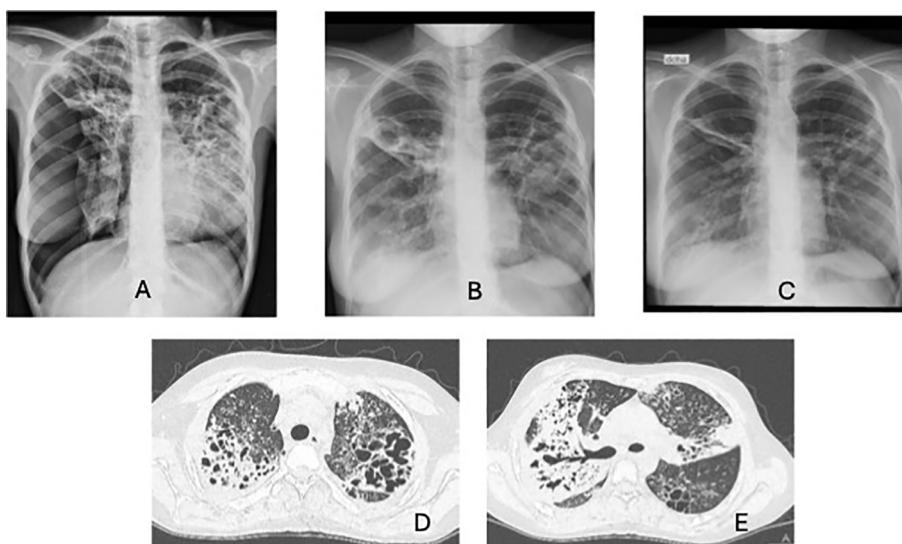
A, B and C: Chest X-rays of case 1 at the start and after 8 months and 12 months of treatment. D and E: Chest CT scans of case 2 showing thick-wall cavities and multiple cystic and varicose bronchiectasis in the upper lobes of both lungs.
